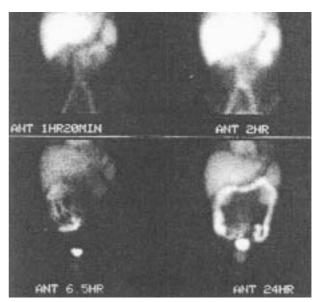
Tc-99m labeled human serum albumin scintigraphy showed increased radioactivity in ileum at 6.5 hour and entire colon at 24 hour.
